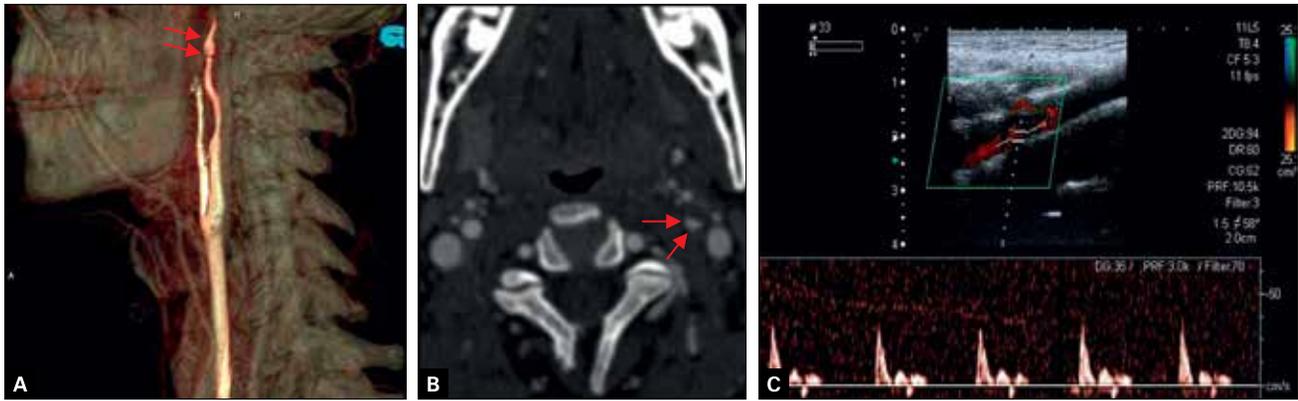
Acute cerebral ischemia in the course of: A. – dissection of the distal portion of the right internal carotid artery (arrows). Angiography. B. – Pulse Doppler ultrasonography shows aberrant high-peak signals in pre-dissected patent portion of ICA consistent in dissecting occlusion of the upper segment of the right internal carotid artery. C. – Pulse Doppler ultrasonography. The normal pattern spectrum flow in the contralateral normal internal carotid artery
